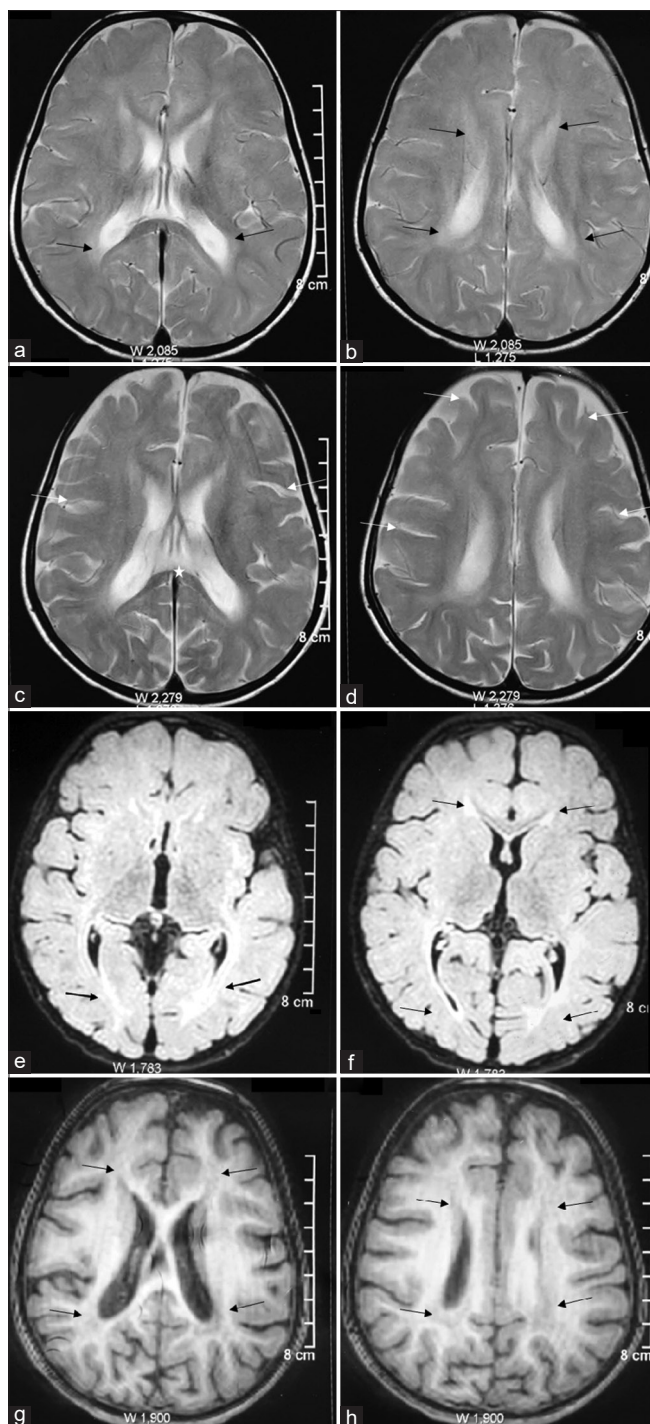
(a-h) Serial MRI scans of the brain (a-b) Axial T2w images show presence of T2w hyperintensities in bilateral periventricular region (black arrows), mild diffuse cerebral atrophy, and thinning of corpus callosum. Three-year follow-up MRI with axial T2w images (c-d) show progression of bilateral symmetrical hyperintensity in periventricular white matter, widened sulcal spaces (white arrows) with corpus callosum volume loss (star) suggestive of brain atrophic changes. The corresponding T2-FLAIR images (e-f) show similar hyperintensities in the white matter (arrows) and the same areas are hypointense on axial T1w images (g-h)
